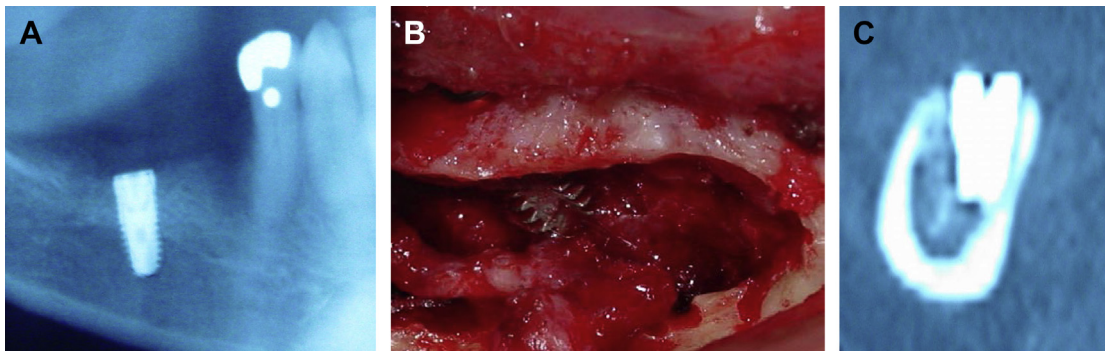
(A) Panoramic radiograph of implant placed into right mandibular canal. (B) Buccal plate bone window created with implant into mandibular canal and neurovascular bundle. (C) Coronal CT scan with implant into canal. (Courtesy of Dr Vincent Ziccardi, Newark, NJ.)
